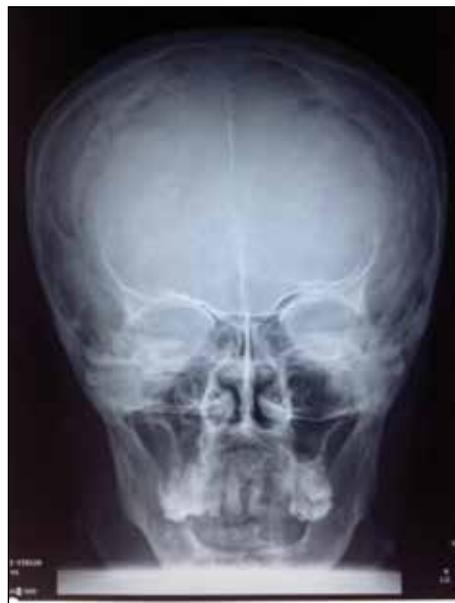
Skull X-ray showing macrocephaly and calcification of the falx cerebri.
